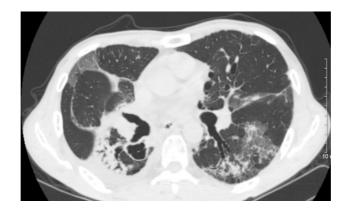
CT chest images after concurrent chemoradiotherapy and 1 cycle of durvalumab
